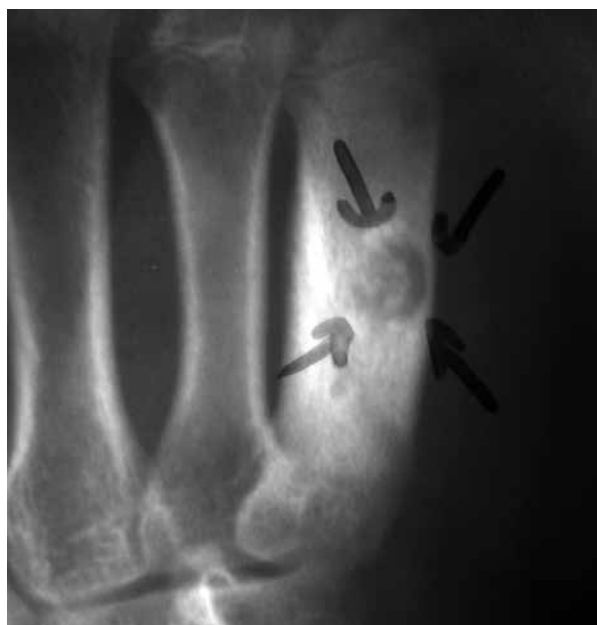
Plane X-ray of the case.
